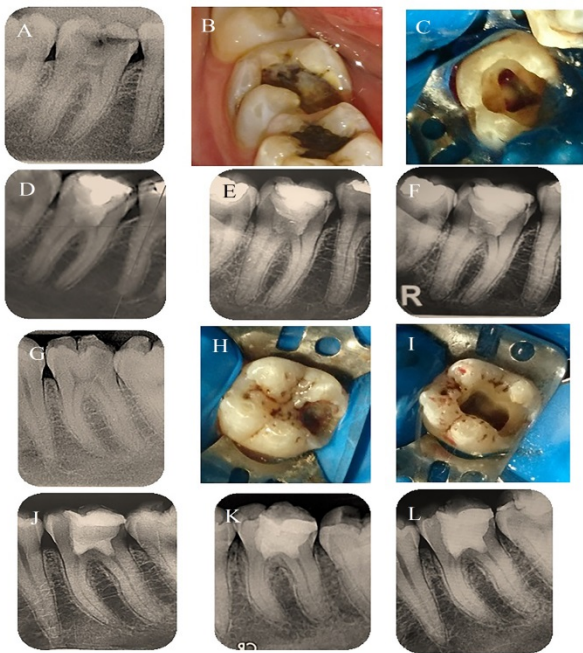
Showing the clinical, & radiographic assessment for the tooth #47 (A-F) & #36 (G-L) in the first case. (A,&G) Pre-operative periapical radiographs for tooth # 47, & #36 respectively; (B,&H) showing pre-operative clinical photos of tooth #47 with extensive occlusal caries, & #36 with extensive occlusodistal caries respectively. (C,&I) clinical photos of tooth #47, & #36 after pulpotomy & control of bleeding respectively; (D-F) periapical radiographs taken immediate post-operative, after 6 months, & after 12 months of follow up respectively for tooth #47; (J-L) periapical radiographs taken immediate post-operative, after 6 months, & after 12 months of follow up respectively for tooth #36.
